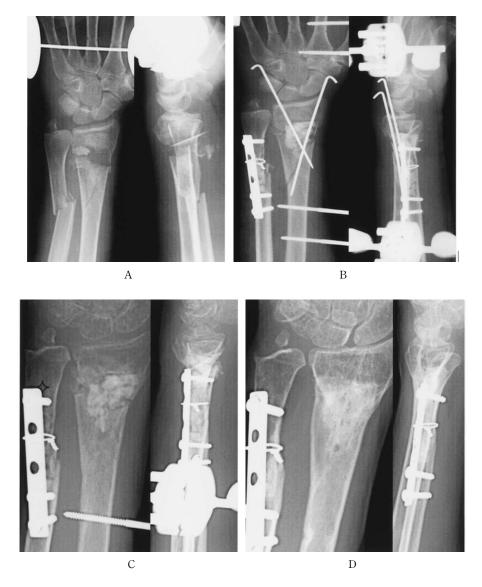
Distal radius fracture with comminution of both the dorsal and palmar bone cortices in a 71-year-old woman²⁰. A. Before surgery. B. Immediately after surgery. Fixation was achieved with an external fixtator, percutaneous Kirshner-wire fixation for the radius fracture and with a plate and wiring for the ulna. Corticocancellous defects were filled with β -TCP. C. After 2 months, partial β -TCP resorption and regeneration of bone trabeculae were seen. D. Radiographs 1 year after surgery demonstrate excellent remodeling of the regenerated bone with bioresorption of β -TCP.
